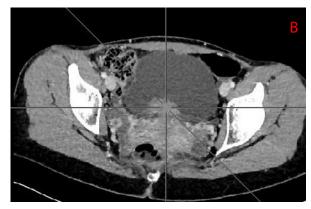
Abdominopelvic CT scan
